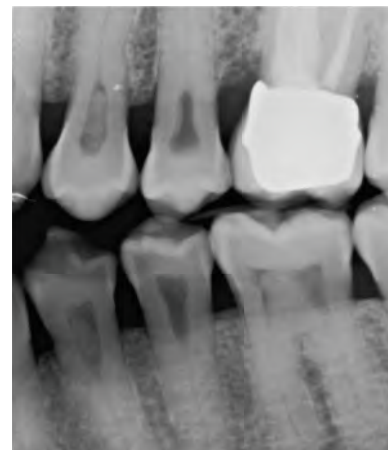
A bitewing radiograph of a patient with *dentinal dysplasia*, type II (coronal). Note the characteristic ‘thistle-tube’ appearance of the pulp chambers and presence of pulp stones in several teeth. (Courtesy of Dr. Carl M. Allen, Columbus, OH.)
